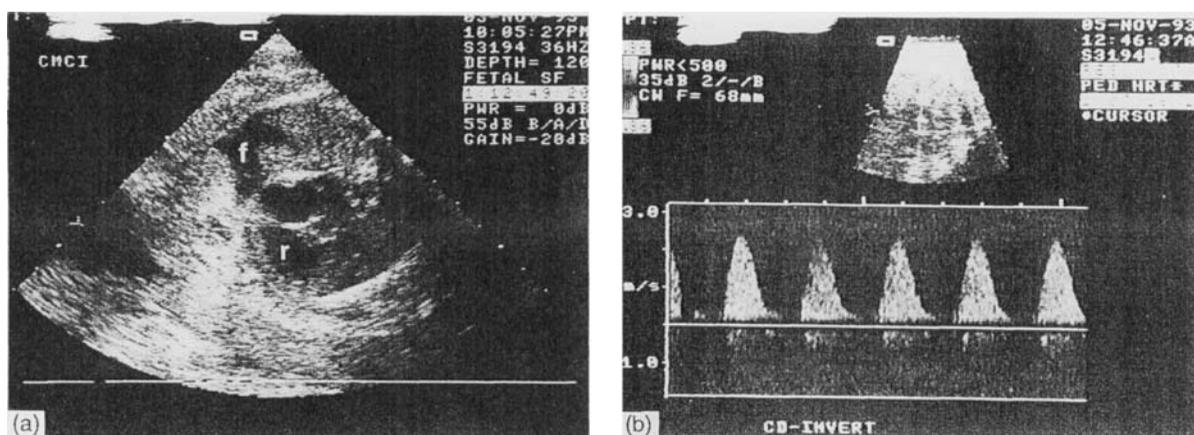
Prenatal ultrasonographic findings: (A) short axis view of the fetal chest showing an enlarged akinetic right ventricle (r) and pleural effusion (f); (B) Doppler wave form from the ductus 2 days after the last dose of indomethacin. A high systolic velocity of 2.6 m/s was recorded
